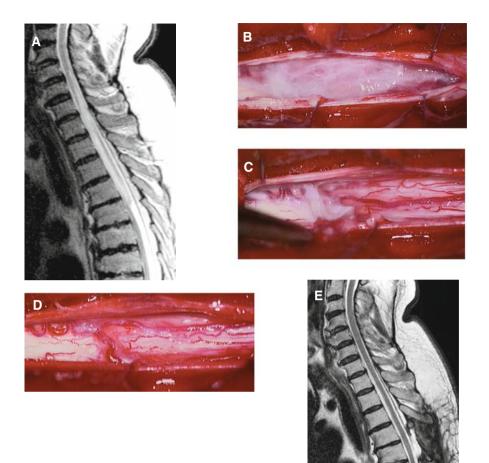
A This sagittal T2-weighted MRI demonstrates a syrinx between C5 and Th4 in a 57-year old man with a 3-months history of painful dysesthesias in his left arm and upper trunk. At the lower pole of the syrinx the spinal cord appears pushed anteriorly and compressed indicating the area of the arachnopathy. B This intraoperative view shows the arachnopathy after dura opening. Above and below the pathology the arachnoid appears translucent again indicating an adequate exposure. Starting at the caudal end the arachnopathy is resected with micorscissors putting the arachnoid under slight tension. C This view shows the upper part of the arachnopathy attached to veins on the posterior cord surface. D At the end of intradural dissection, this view shows a free CSF passage across the area of surgery. Note the small remnants of thickened arachnoid left on the spinal cord to preserve the large posterior veins. The dura is closed with a spacious graft. E The postoperative MRI after 10 months shows a perfect result with decompression of the cord at Th4, a free CSF passage and a complete resolution of the syrinx. Three months after surgery the dysestes sias had vanished and have not recurred since
